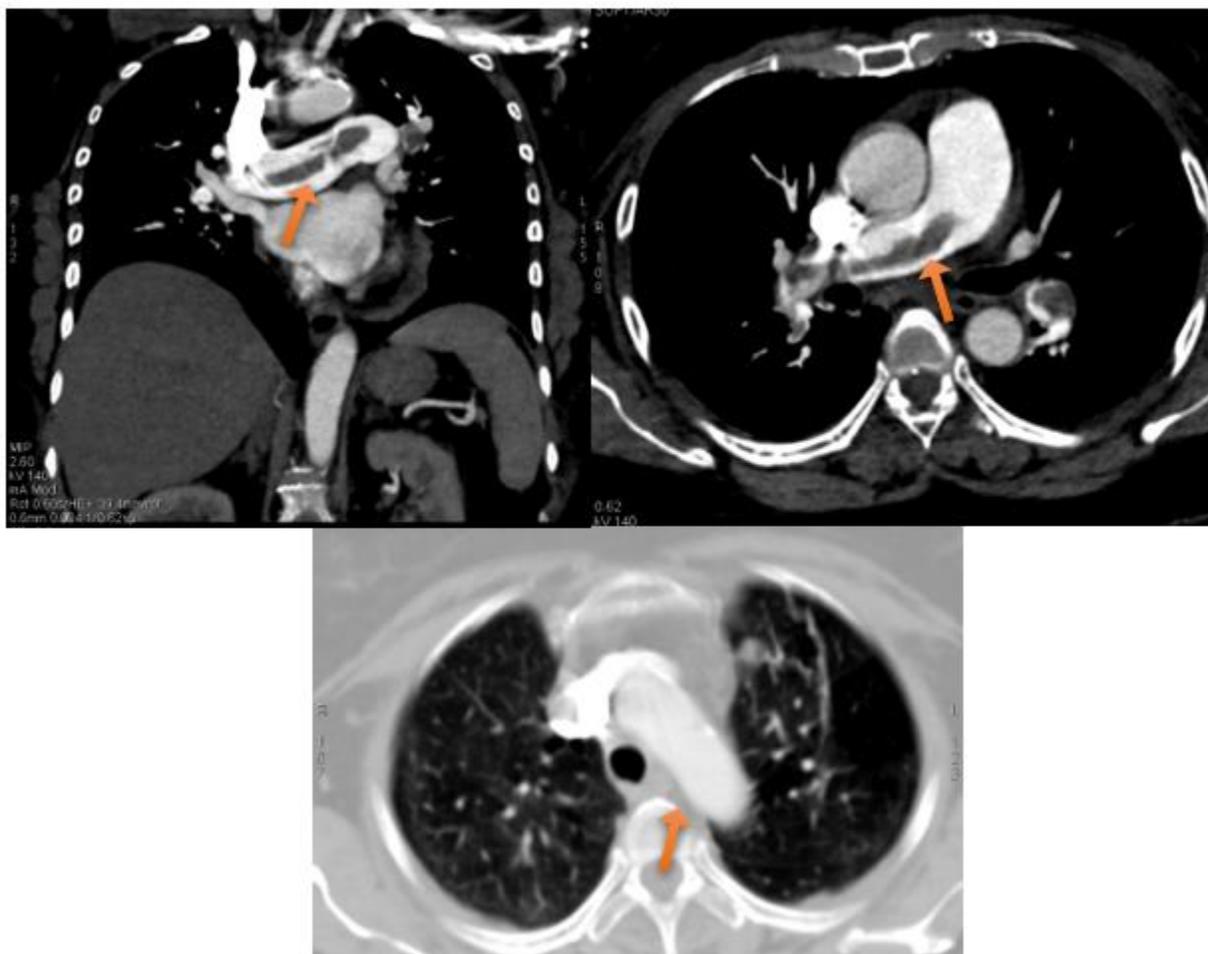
CT Pulmonary Angiography showing Pulmonary Thrombosis
